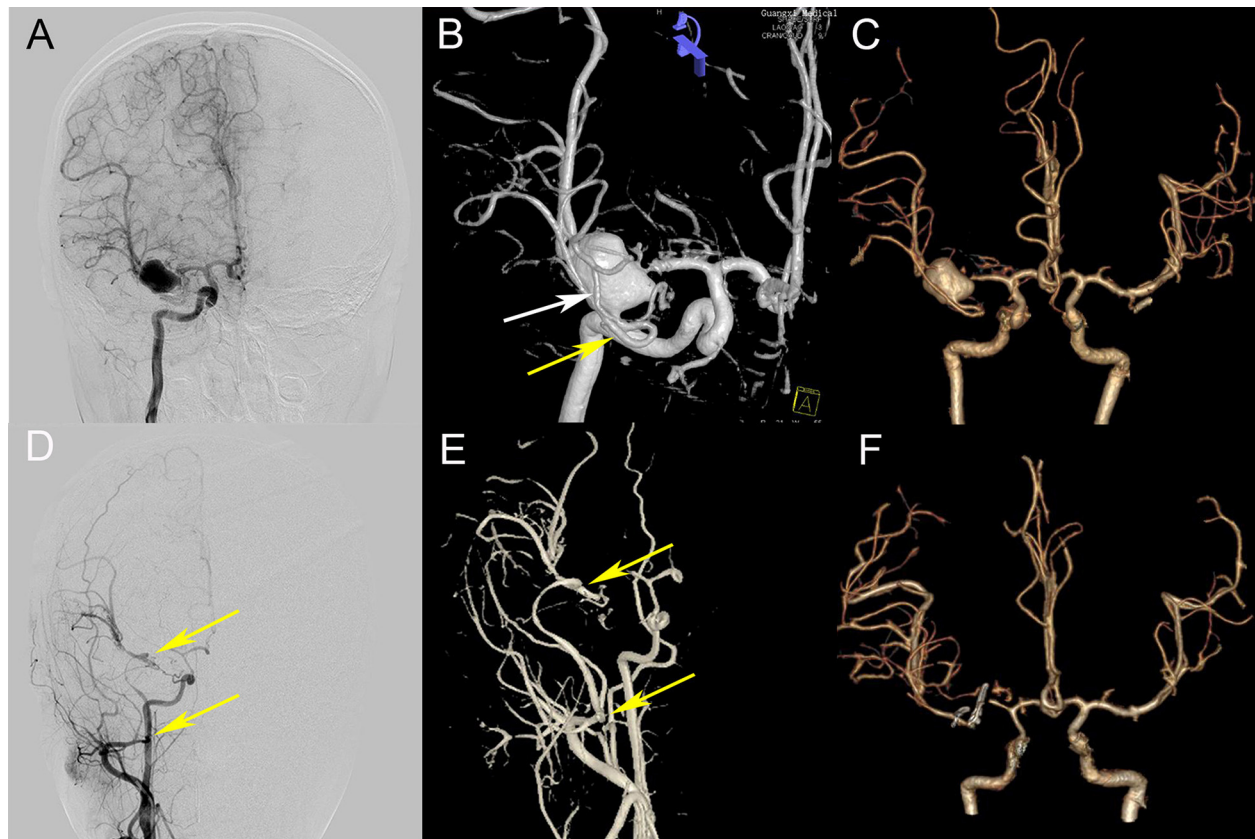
Preoperative and postoperative comparison. (A,B) Preoperative DSA (A, frontal view; B, anterior upper view) showing an aneurysm at the bifurcation of M1, a small outflow path (the white arrow) and a larger outflow path (the yellow arrow) at the lateral side of the aneurysm; (C) Preoperative CTA 3D reconstruction; (D,E,F) Postoperative DSA and CTA showed that the IMX-RA-M2 bypass artery was patent (two yellow arrows indicate the RAG anastomosis), the aneurysm disappeared, and the distal artery of MCA was clearly developed (comparing C and F).
